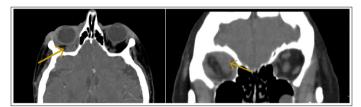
An Axial (Left) and Coronal (Right) Cut of a CT Scan Demonstrating a Diffuse Tumor in the Right Orbit
